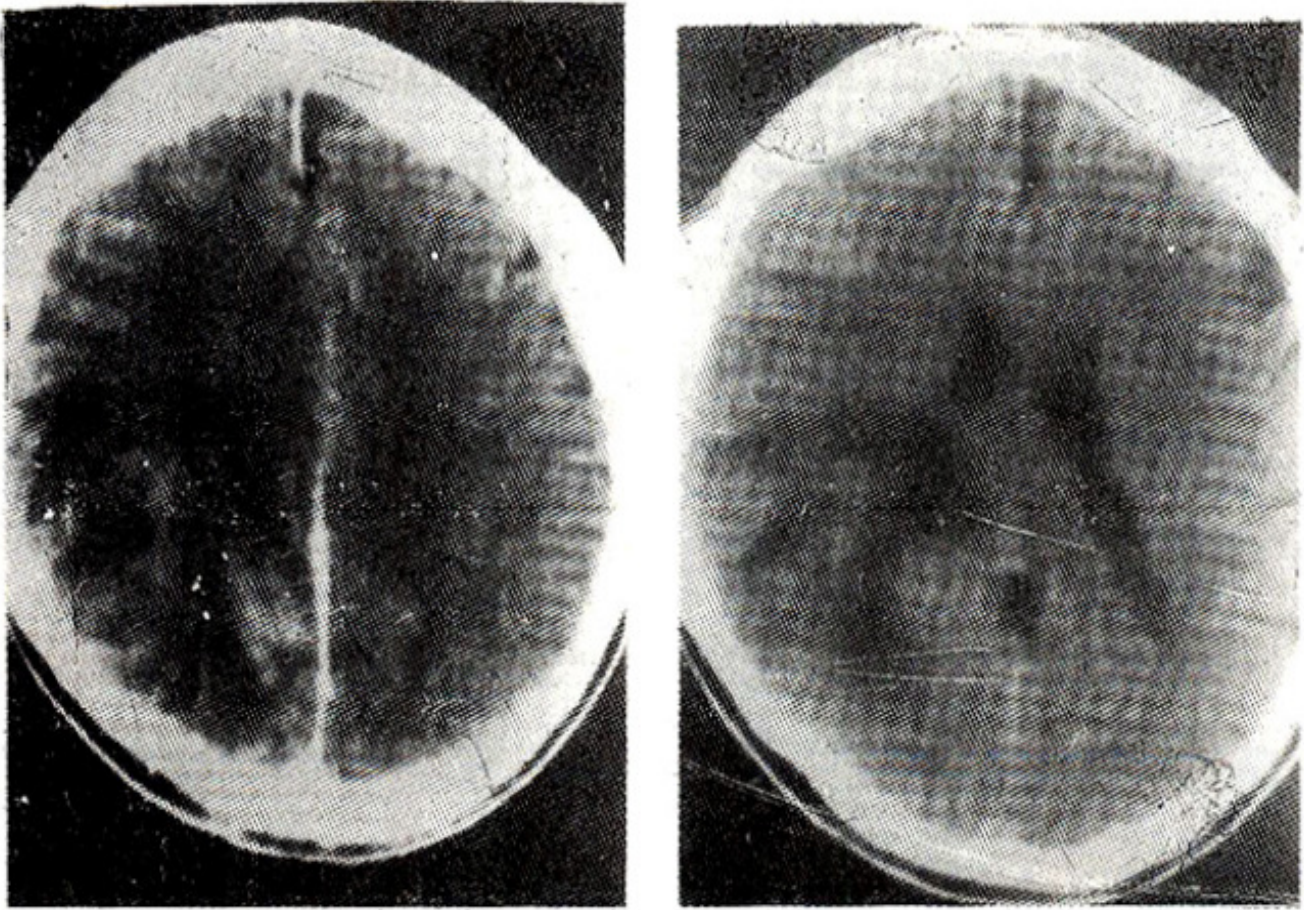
Non-contrast [L: + 30, W: + 100] (a) and contrast enhancement [L: + 28, W: + 100] (b) CT scan of head showing a large area of mixed density in right parieto-occipital area without any contrast enhancement. No significant midline shift is seen.
